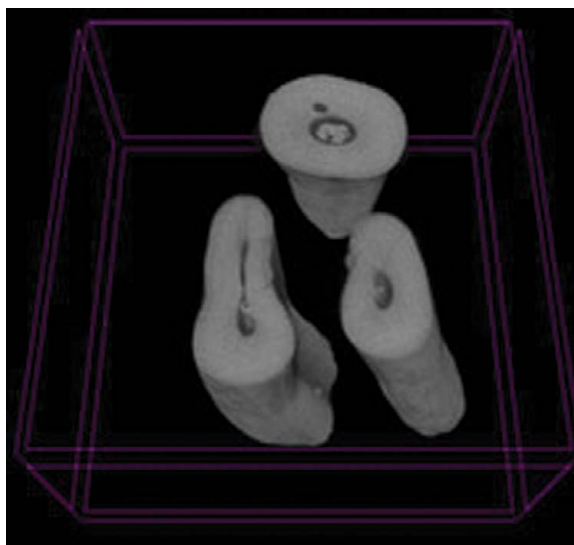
Three-dimensional image of root canal system of human teeth in micro-computed tomography analysis (SkyScan 1172, Bruker).
